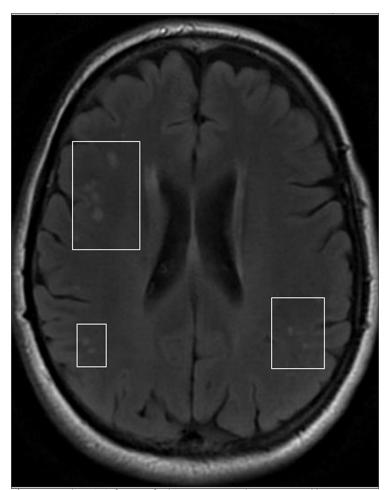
Ischemic infarcts of white matter as demonstrated by T2 FLAIR MRI
